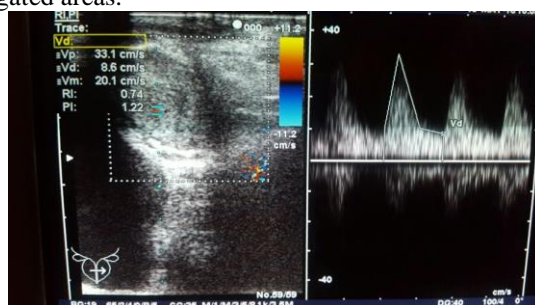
Sonogram of the prostate gland (transrectal ultrasound examination with determination of resistance index).
